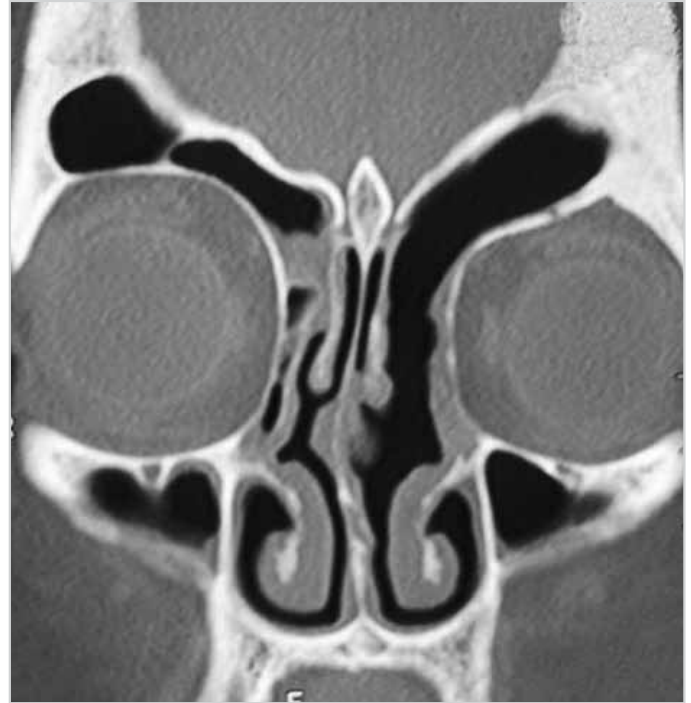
Postoperative 3rd month CT scan
